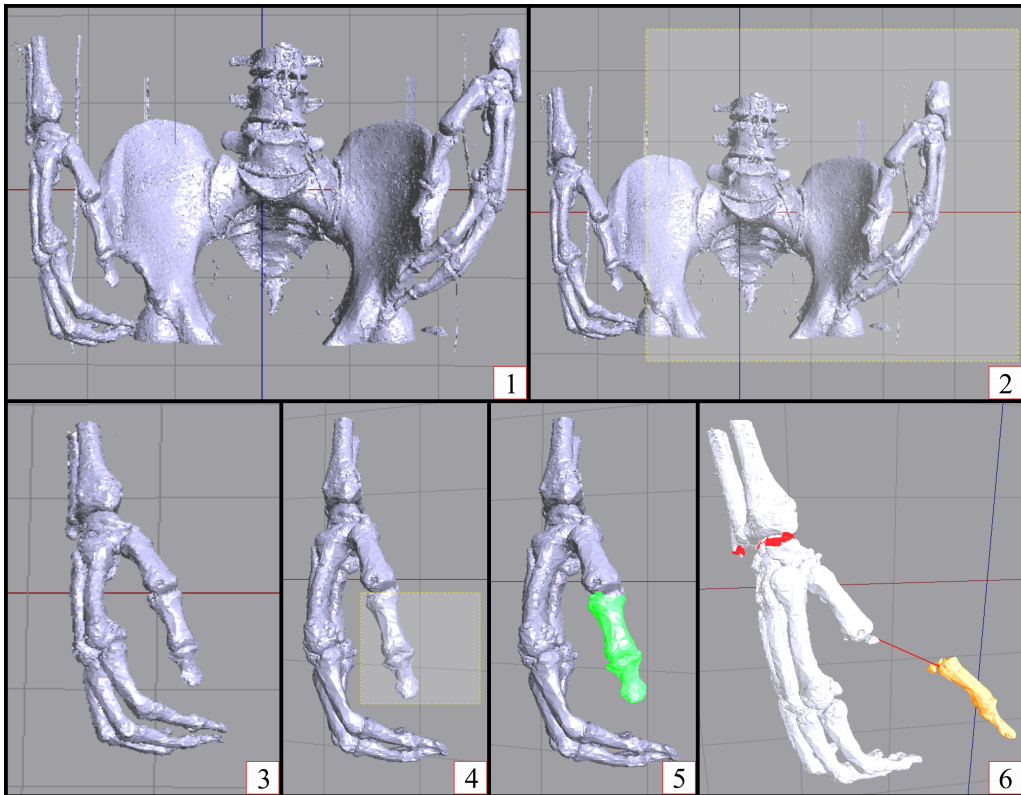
Example of using the application. 1 - Triangle soup generated from CT scans. 2 - Selection of some unnecessary triangles. 3 - Cleaned scene. 4 - Selection of a model. 5 - Selected model. 6 - Interaction with defined models.
